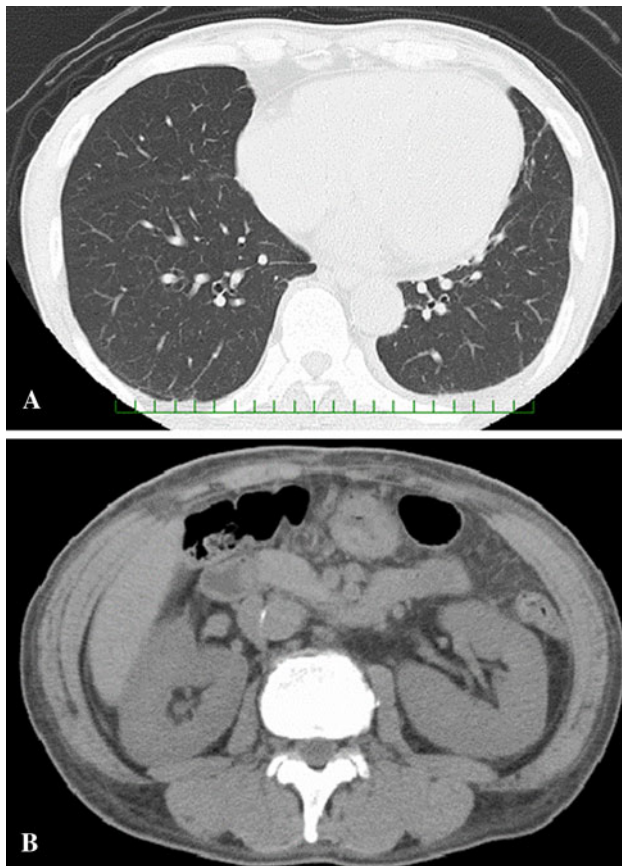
a Chest CT scan. No findings of interstitial pneumonia were found. b Abdominal CT scan. Both kidneys were swollen but no signs of hydronephrosis were observed
